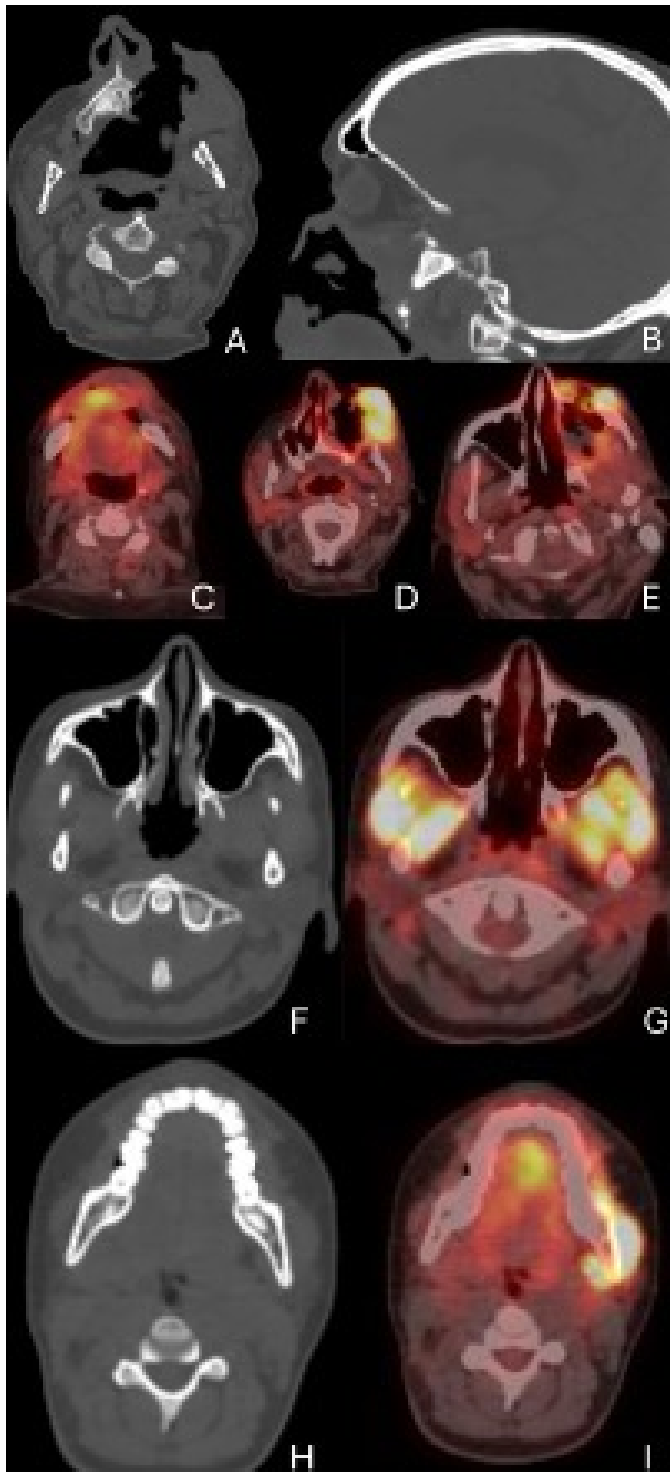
A 66-year-old male with sinonasal carcinoma invading the maxilla and maxillary sinus region (A, B), demonstrating high metabolic activity on FDG-PET/CT imaging (C, D, E). A 19-year-old female presenting with increased metabolic activity observed in the masseter and medial pterygoid muscles bilaterally, attributed to temporomandibular overuse, as depicted on PET/CT imaging. The patient had no previous TMJ pathology diagnosis (F, G, H, I).
